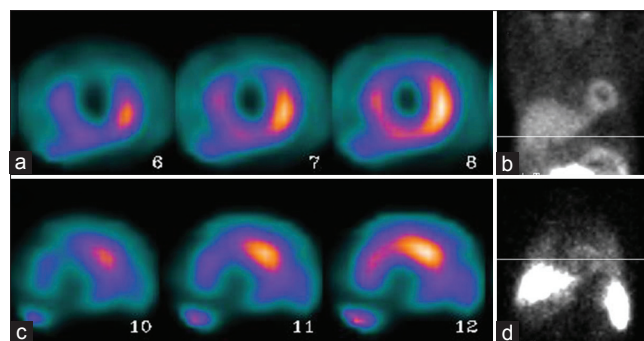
(a) The short axis images of technetium-99m (Tc-99m)-MIBI myocardial perfusion single-photon emission computed tomography (SPECT) performed at rest reveal perfusion defect in anterior wall and apex; consistent with scarred myocardium (upper row). (b) Planar image showing the biodistribution of Tc-99m-MIBI. (c) The corresponding short axis images of Tc-99m-HMPAO labeled stem cells SPECT study show localization of labeled stem cells in the region of infarct (lower row). (d) Planar image showing the biodistribution of Tc-99m-HMPAO labeled stem cells in liver, spleen and infarcted myocardium
